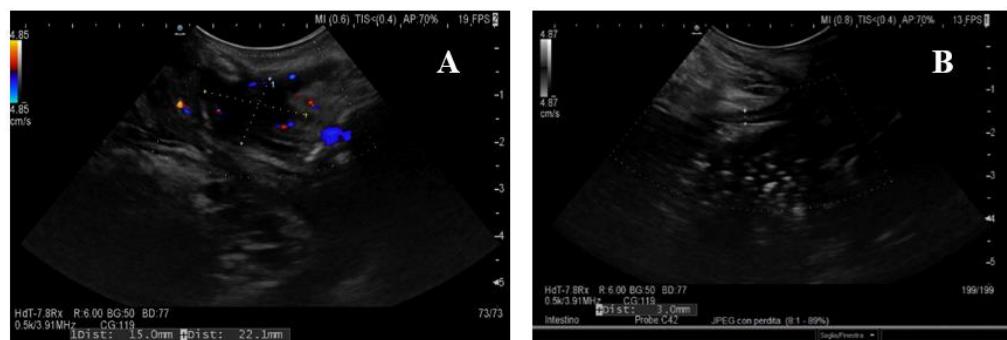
Ultrasonographic findings of transperineal ultrasound (TPUS). (A) A perianal abscess in an operated CD patient with typical peripheral color Doppler signal. (B) The wall of an ileal pouch is measured with the transperineal approach. CD: Crohn's disease.
